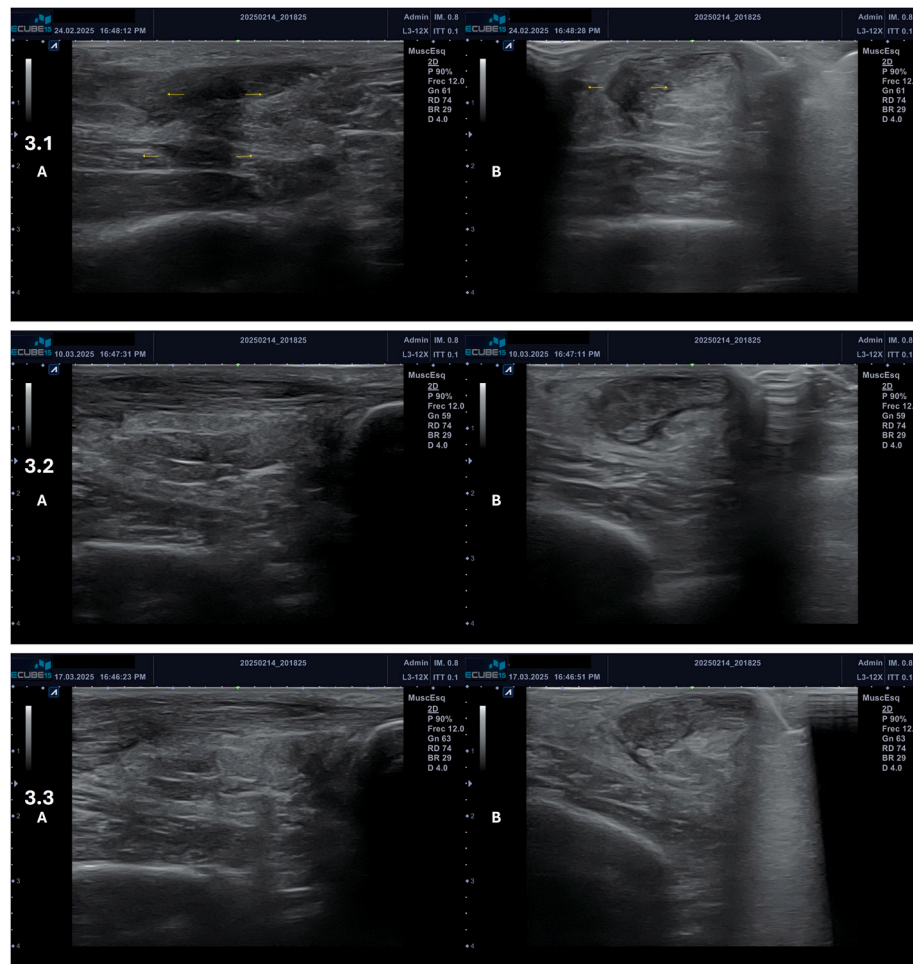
Follow-up visits ultrasound images: 3.1 Follow-up visit 1 (1 week after injection): Longitudinal (A) and transversal (B) views where the ultrasound images showed a partial, almost complete recovery of the affected structures, with evident signs of tissue regeneration of the broken fibers of the Achilles tendon and the disappearance of the soleus disruption (proliferative phase). 3.2 Follow-up visit 2 (2 weeks after injection): Longitudinal (A) and transversal (B) views where the ultrasound images showed complete recovery of the affected fibers, with a density and composition different from healthy tissue, but no rupture was observed. 3.3 Follow-up visit 3 (3 weeks after injection): Longitudinal (A) and transversal views (B) where the ultrasound images showed the beginning of tendon fiber alignment, indicating the start of the remodeling phase.
